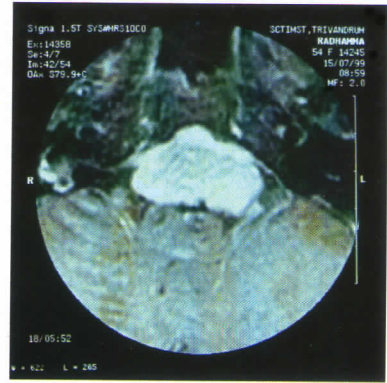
a : Post contrast MRI of a patient with large anterior foramen magnum meningioma
